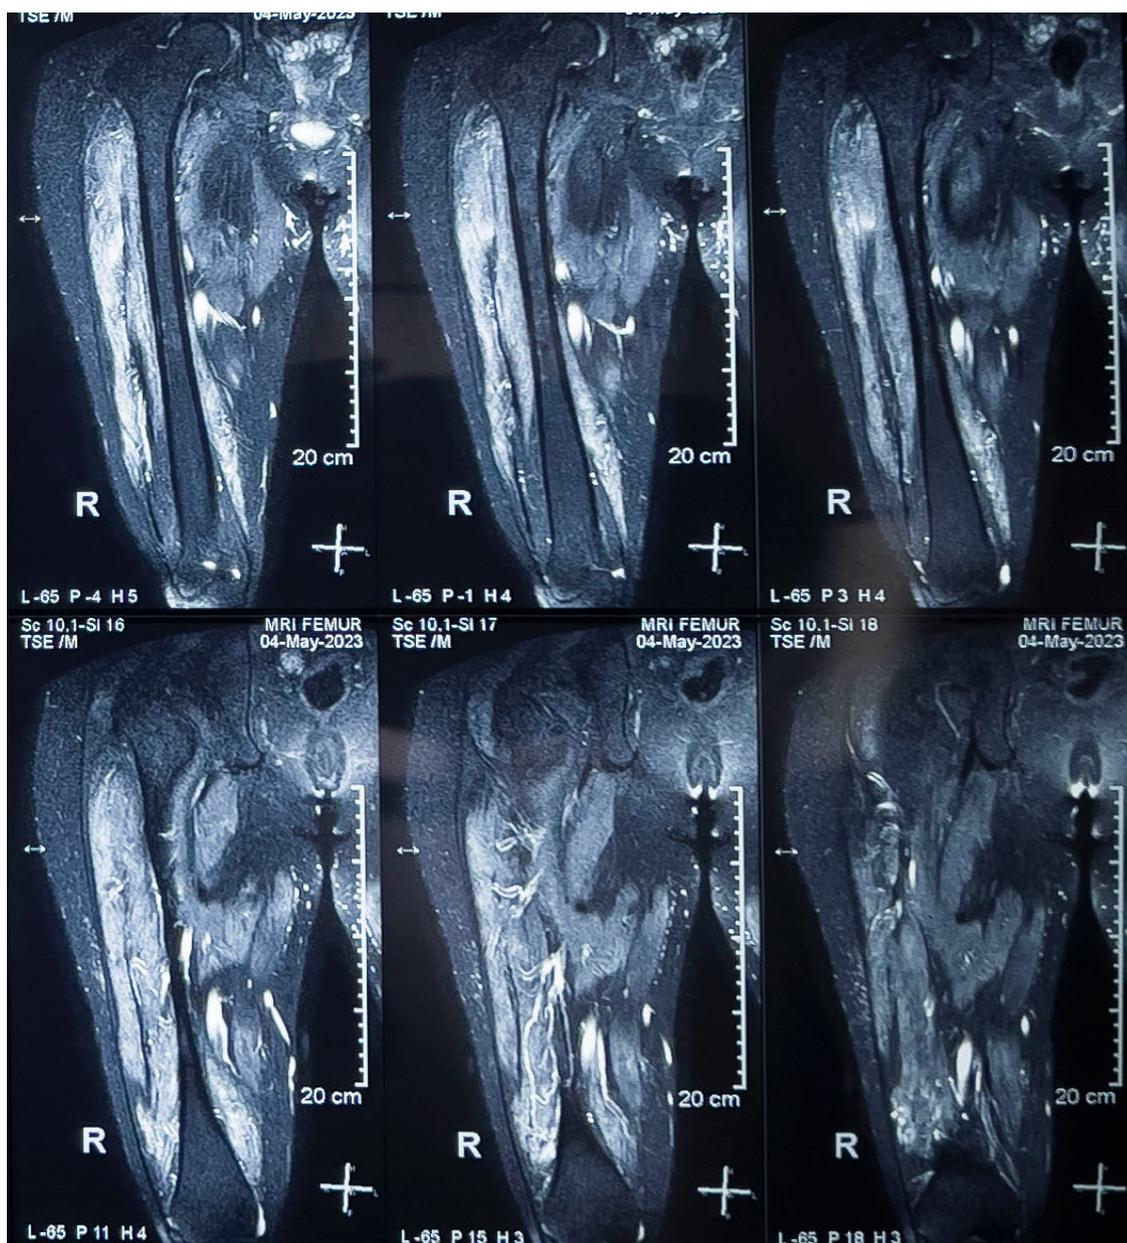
Magnetic resonance imaging (MRI) findings on right femur muscle show intensity changes with atrophy of the vastus medialis, intermediate, lateralis and biceps femoris muscles that indicates myositis.
